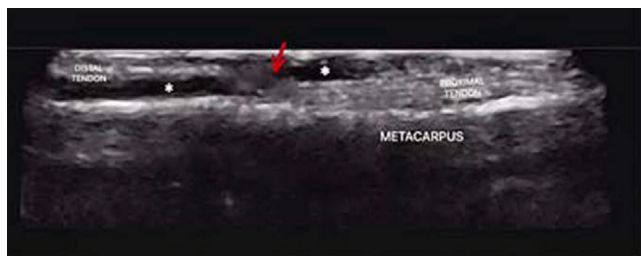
Ultrasound image revealing hypoechoic peritendinous edema (*) and a focal hypoechoic area consistent with fibrotic scarring of the extensor digitorum tendon (red arrow).
